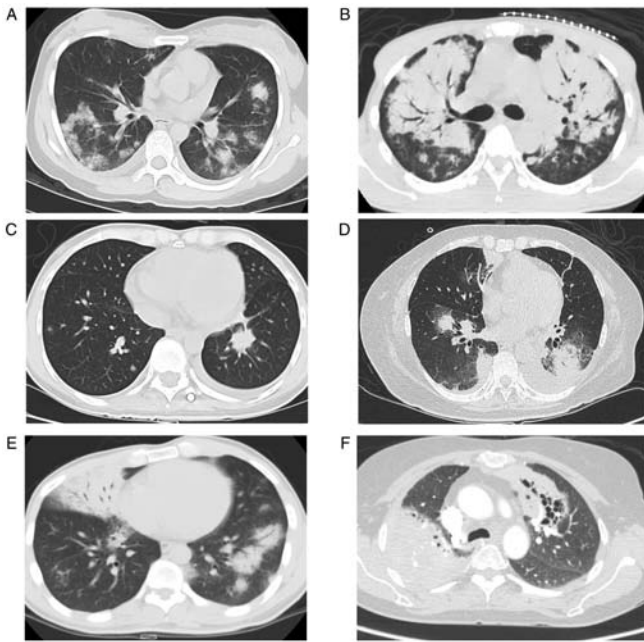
Thoracic computed tomography scans of patients with primary pulmonary non-Hodgkin's lymphoma. (A) Anaplastic large-cell lymphoma with multiple bilateral pulmonary infiltrates. (B) Peripheral T-cell lymphoma-unspecified with bilateral pulmonary consolidation, with air bronchogram. (C) Diffuse large B-cell lymphoma with multiple bilateral pulmonary nodules. (D) Natural killer/T-cell lymphoma with multiple masses, with a halo of ground-glass opacities, air bronchogram and a non-specific 'crazy paving' pattern in both lungs, plus small left pleural effusions. Mucosa-associated lymphoid tissue with (E) multiple bilateral pulmonary nodules and consolidation with air bronchogram, and (F) a mass with calcification in the right upper lobe, as well as patchy shadows with a honeycomb pattern in the left upper lobe.
